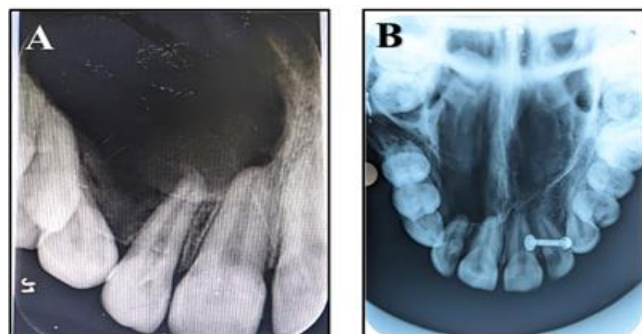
Pre-operative IOPA (A) and Occlusal (B) radiographs of the patient
